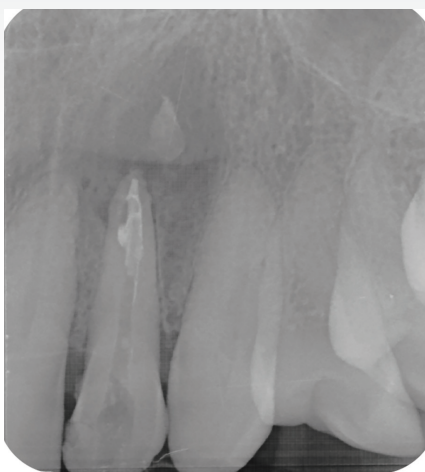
Mid-fill periapical showing apical plug of gutta percha
